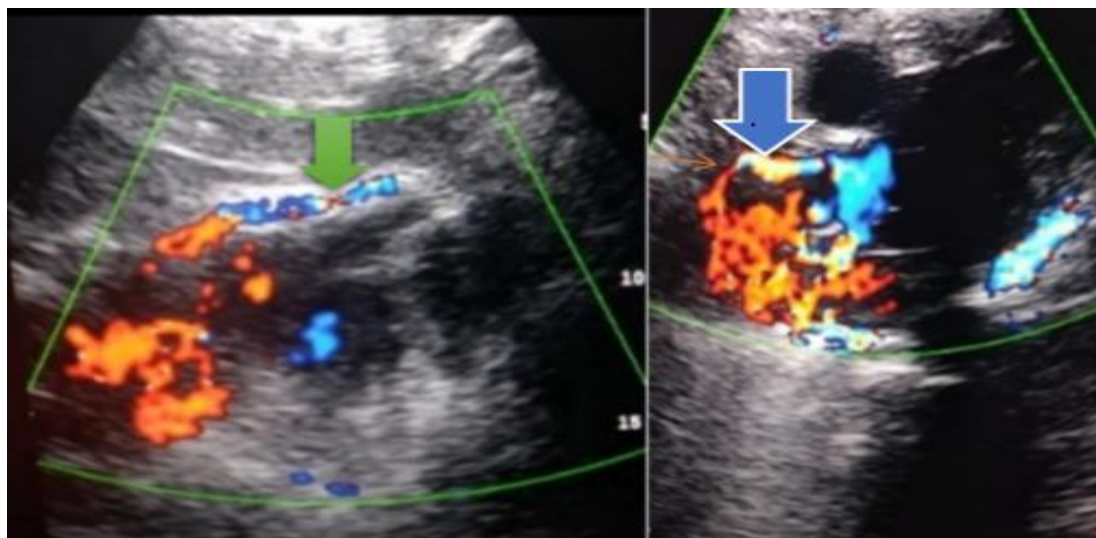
subcostal (right) & apical parasternal (left) views; show severely stenotic PD-CA (green arrow), and branch of right CA (red arrow) with pre-stenotic dilatation (white blue arrow), with Rt. to Lt. blood supply.
